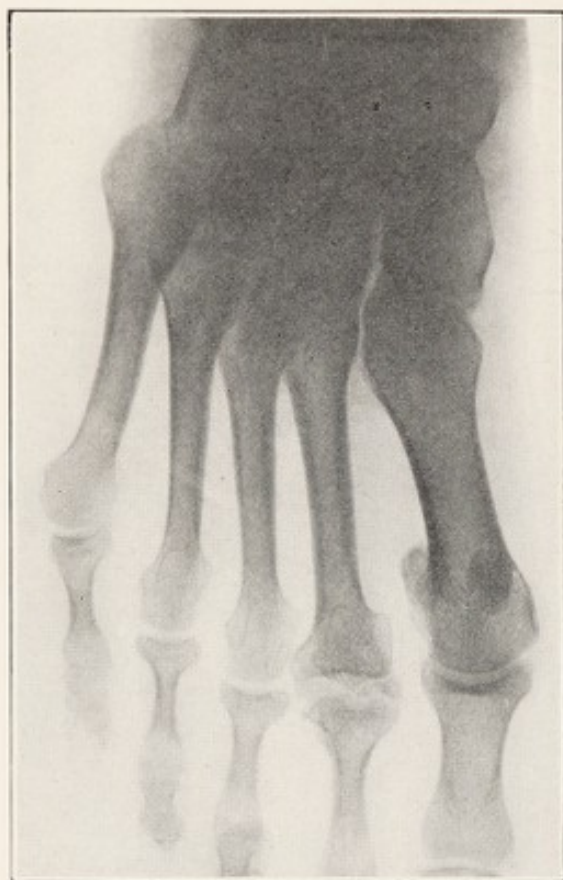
X-RAY OF OSTEOCHONDritis OF HEAD OF SECOND METATARSAL, SHOWING TYPICAL CORPORA LIBERA IN THE JOINT.
